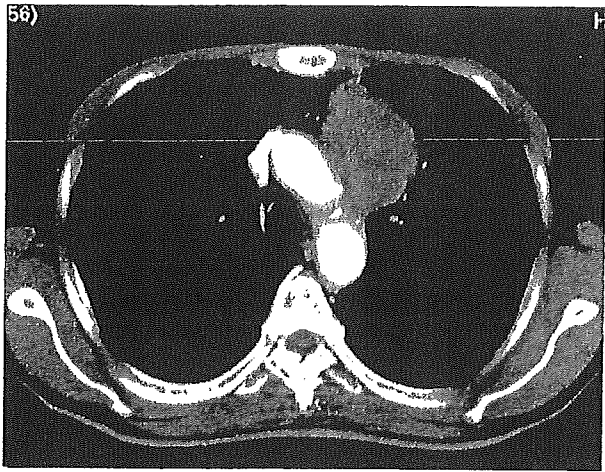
Computed tomography of the chest revealing a localized mass in the anterior mediastinum.
